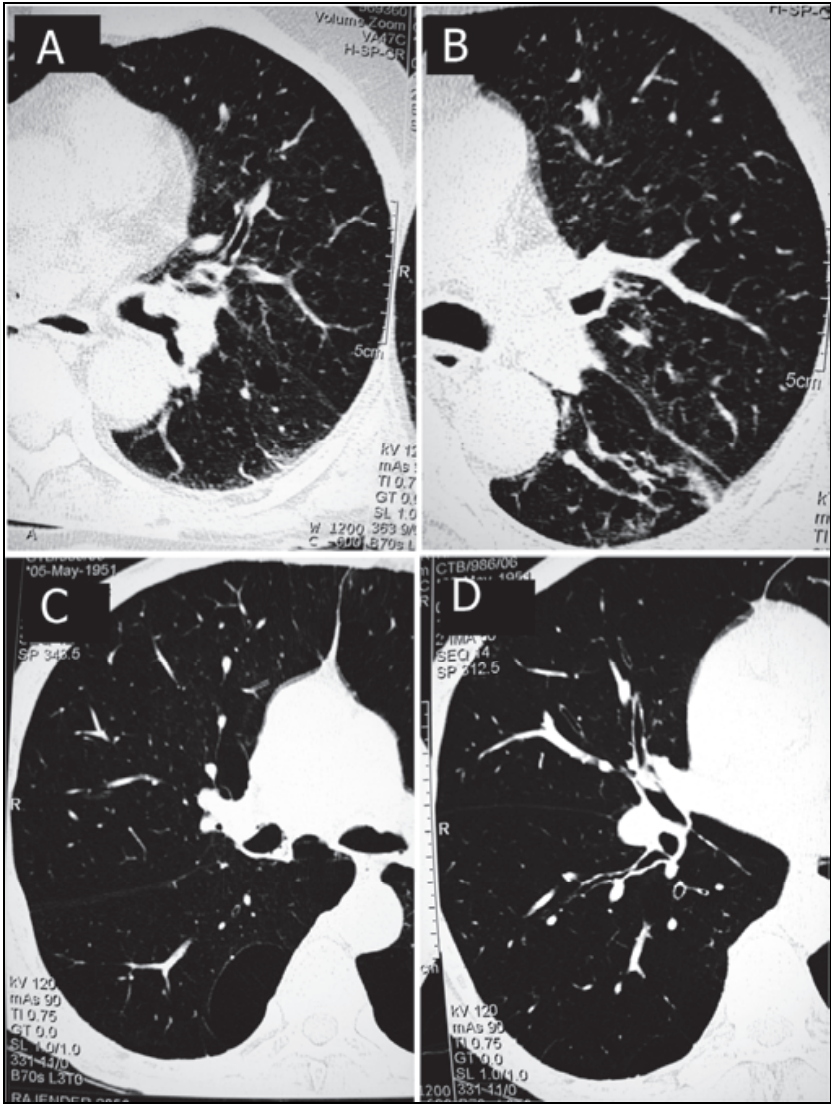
(A-D): HRCT axial scans from COPD patients showing vascular distortion characterized by increased branching angles and excessive straightening of pulmonary vessels.
